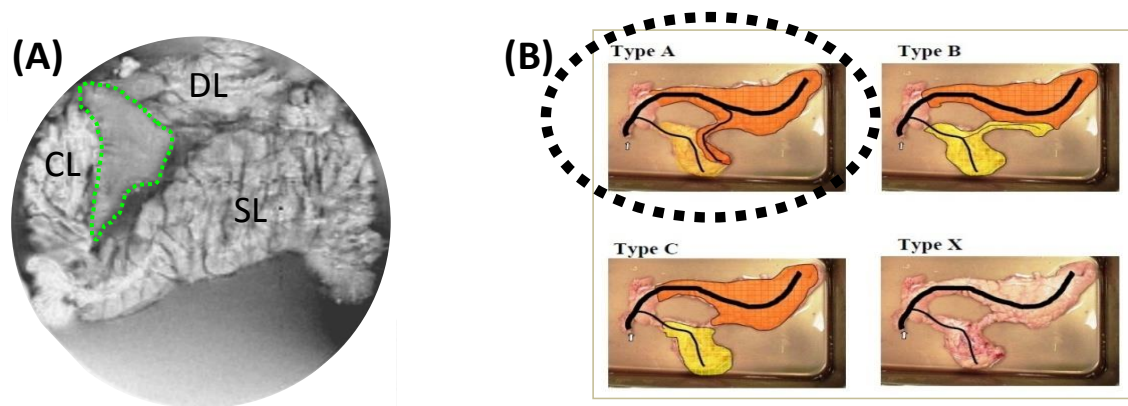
Ductal MRI cannulation approaches. Pictures depicting the different cannulation and infusion methods: (A) Traditional method separating the pancreas into 3 distinct lobes with anterograde infusion of the main ducts (Method 1); (B) Separation of the duodenal lobe with anterograde infusion into divided pancreas via cannulation of the main ducts with the bridge left intact (Method 2); and (C) Cannulation of main pancreatic duct at the papilla and infusion of total amount of contrast (Method 3).
